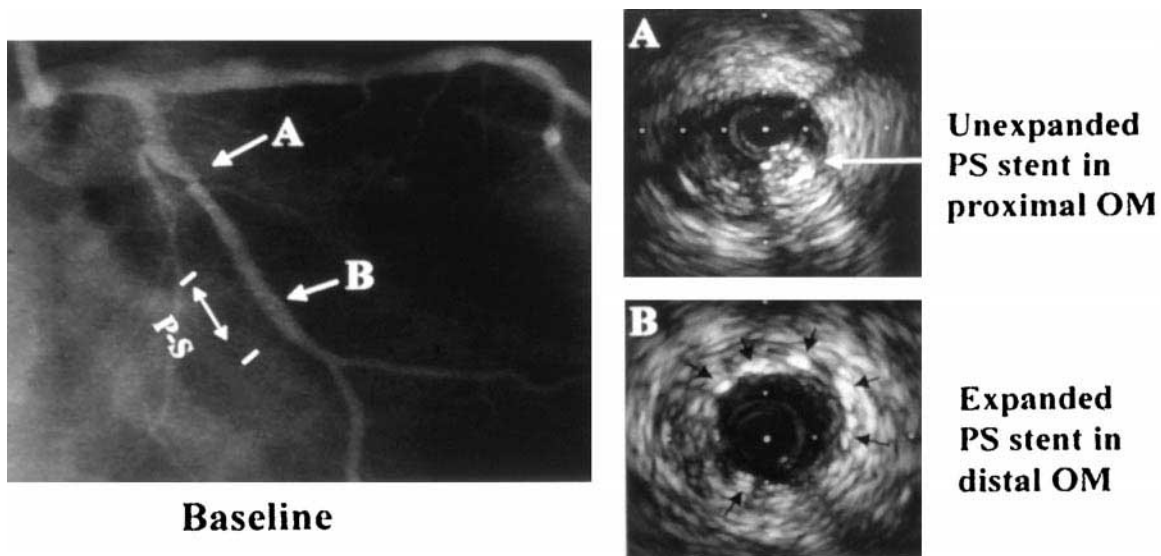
A Palmaz-Schatz stent was placed with great difficulty in the distal portion of the obtuse marginal artery. During the struggle to place a second Palmaz-Schatz stent in the proximal segment, the guiding catheter and guide wire suddenly flipped out of the artery. When the balloon was examined, the stent was not present. It was not known if the stent had been stripped off in the coronary artery or embolized in the aorta. After rewiring the artery, the ultrasound image (A) showed an unusual pattern where the echogenic stent struts were seen at the 4-o'clock position in a collapsed state to the side of the ultrasound catheter. For comparison, the IVUS image shown (B) reveals the circumferential struts of the adequately placed first Palmaz-Schatz stent in the distal section of the artery.
